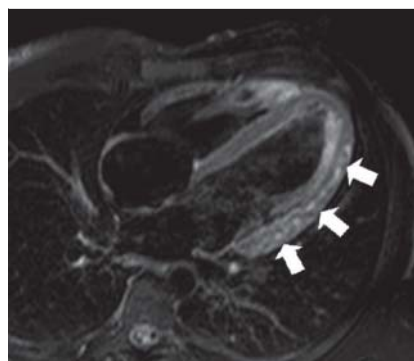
T2-weighted magnetic resonance imaging. Focal areas (white arrows) of high signal intensity within the lateral wall of the left ventricle (4-chamber view), indicating regional myocardial edema.
